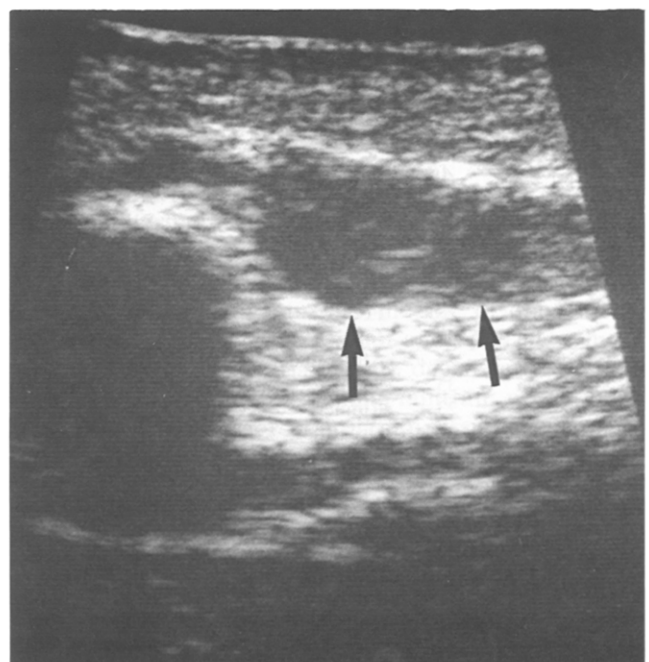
Ultrasound of an abnormal patellar tendon with enlargement and reduced echogenicity of the tendon (arrows).
